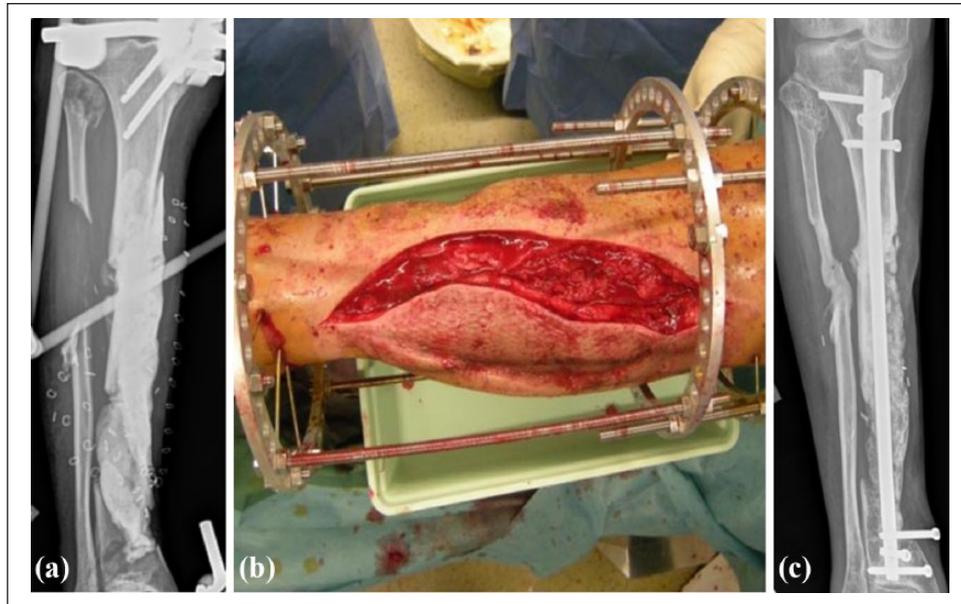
(a) Radiographical view of a right fibula bone loss, after a road traffic accident in a 24-year-old woman, with an external fixator. (b) Surgical procedure with the use of allogeneic bone chips. (c) Radiographical view 4 months later (courtesy of Dr D. Brinkert).
